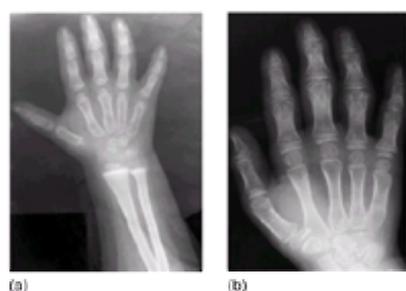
(a) The initial hand radiograph of the patient in [Fig. 2](#) was regarded as normal, although bony changes are starting in the phalanges. By the time bony enlargement was obvious (b) the radiograph shows marked widening of the phalanges at the proximal and distal interphalangeal joints, as well as alteration in texture and epiphyseal changes.
